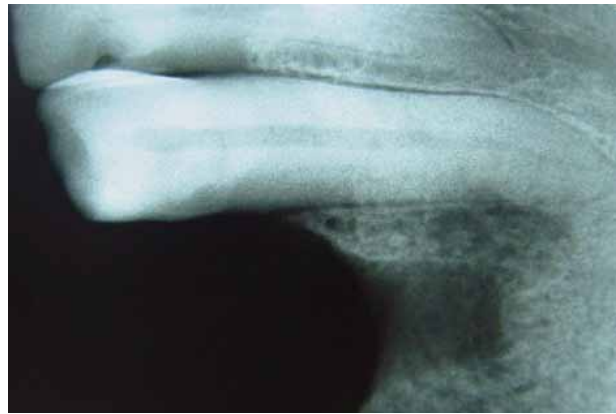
IOPA Radiograph of 43 region, showing ill-defined bone loss
